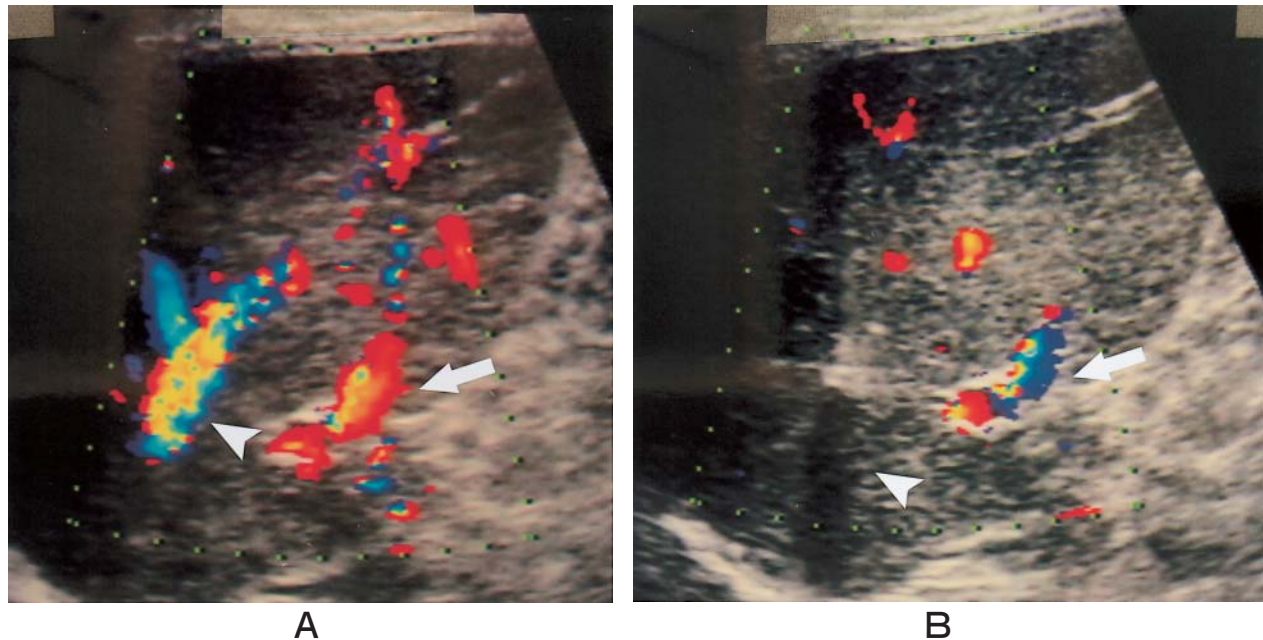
Color Doppler images in the occluded area before (A) and after (B) RHVO. Doppler signal of the PV branch in the occluded area (arrows) changes from hepatopetal before RHVO to hepatofugal after RHVO. Doppler signal of the RHV (arrowheads) changes from hepatofugal before RHVO to no signal after RHVO. (Panels (A) and (B) are reprinted with permission from Hiraki T., *Altered Hemodynamics in the Liver Caused by Temporary Occlusion of the Hepatic Vein: Evaluation with Doppler Ultrasonography in 14 Patients*. *Radiology* (2001) 220: 357-364.)
